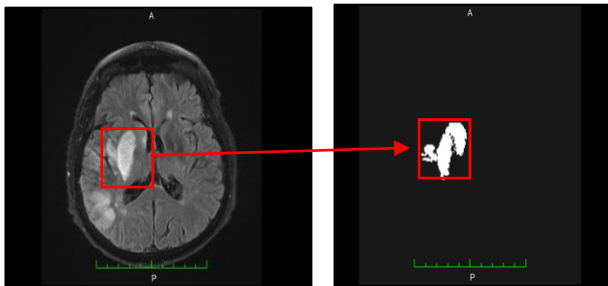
One slice of sample brain FLAIR and label image (left) and ROI (right)
